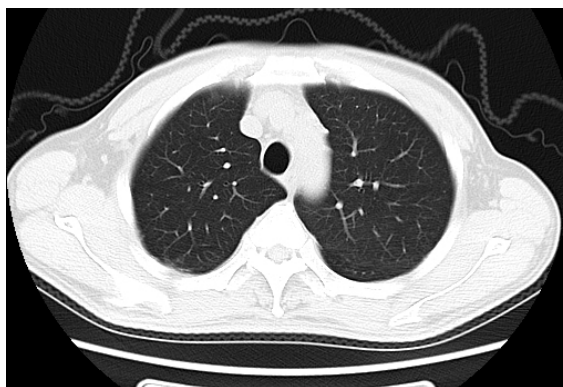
Review of lung CT.
